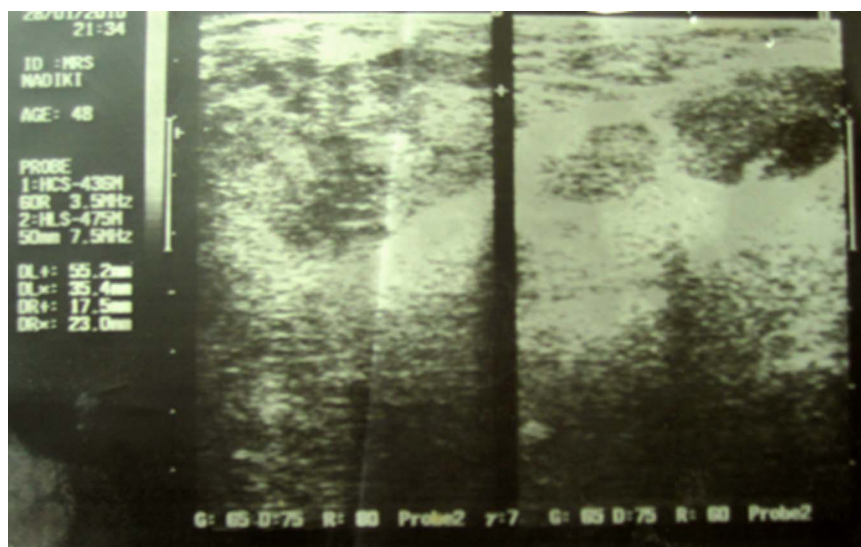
Ultrasound showing a hypoechoic and non-homogeneous mass.
